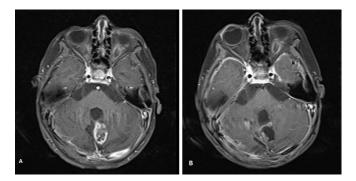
A) Axial post-contrast T1 pre-operative MRI image of tumor before second operation (case 1). B) Axial post-contrast T1 post-operative image showing resection of the lesion.
